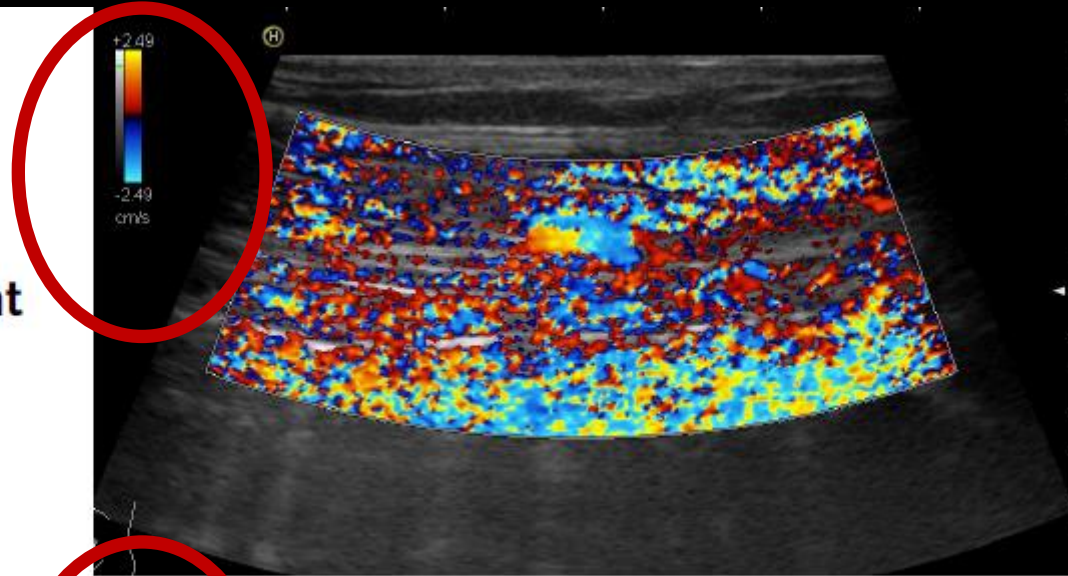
Image optimisation – Colour Doppler
